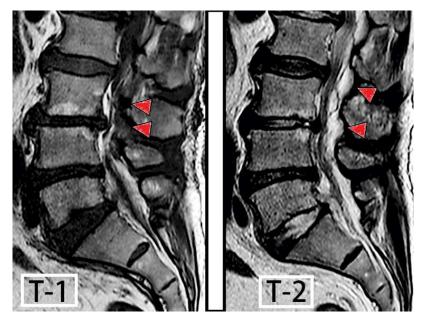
Sagittal T1-weighted, T2-weighted images of the lumbar spine showing a lumbar epidural abscess. The T1-weighted image to the left shows low signal intensity whereas the T2-weighted image shows high signal intensity. (Image courtesy of Spinal Epidural Abscess: A Review Highlighting Early Diagnosis and Management. JMA J. 2020;3(1):29-40.)
